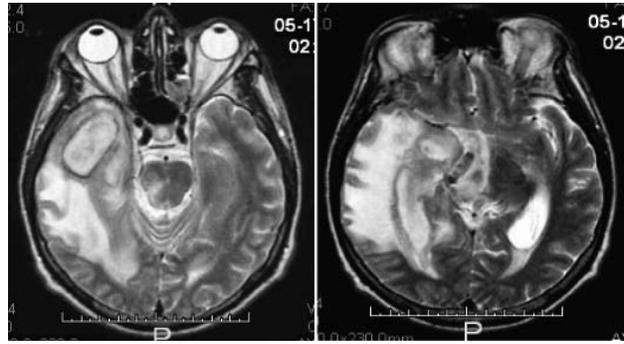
Figure V & VI: Heterogeneous hyperintense lesions in the right inferior temporal area in T2-weighted MR imaging.
